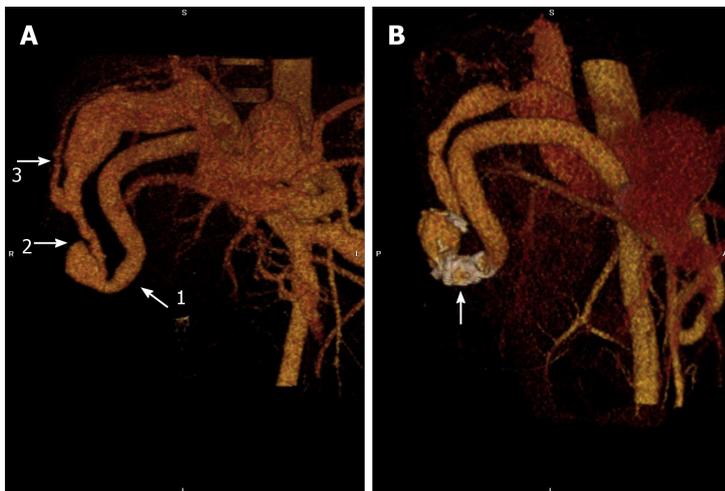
Contrast-enhanced computed tomography scan of the upper abdomen before and after coil embolization. A: Three-dimensional computed tomography reconstruction demonstrated the hypertrophied right hepatic artery (11.8 mm, white arrow 1), the large arterioportal fistula (12 mm in diameter, white arrow 2), and the right portal vein (23.6 mm, white arrow 3). There is a round irregular vascular malformation (28 mm \times 27.1 mm \times 22.4 mm) around the fistula; B: There was a reduction in the right hepatic artery (9.5 mm), arterioportal fistula (5.8 mm) and right portal vein (11.1 mm) after embolization. The site of coil embolization in the distal part of the right hepatic artery is visible (white arrow).
